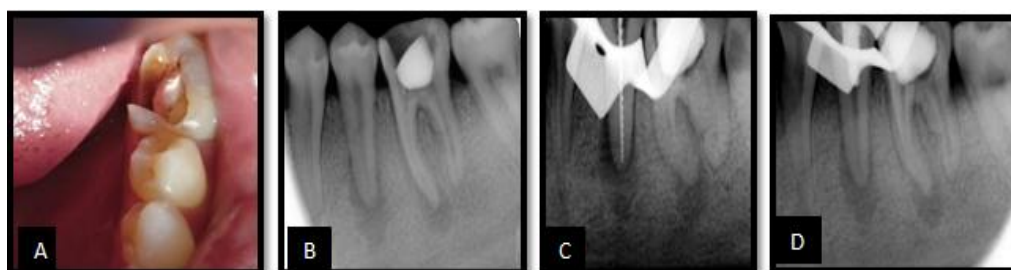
A: Pre- operative intraoral photograph. B: Routine intraoral periapical radiograph showed large periapical radiolucency in 35 and 36. C: Working length determination in 35. D: Immediate post treatment radiograph.
